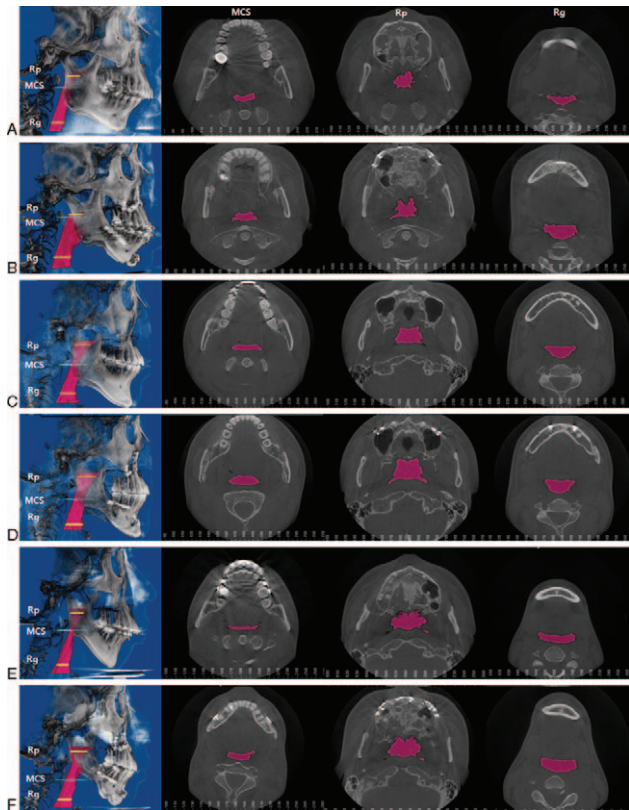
(A–F) Outcome measures assessing the dimensional improvements of upper airway on cone beam computed tomography images. Preoperative images of (A) patient 1, (C) patient 2, and (E) patient 3. Postoperative images of (B) patient 1, (D) patient 2, and (F) patient 3. The cross-sectional areas were measured: (second column) minimum cross-sectional (MCS) level; (third column) retropalatal (Rp) level; (fourth column) retroglottal (Rg) level.
